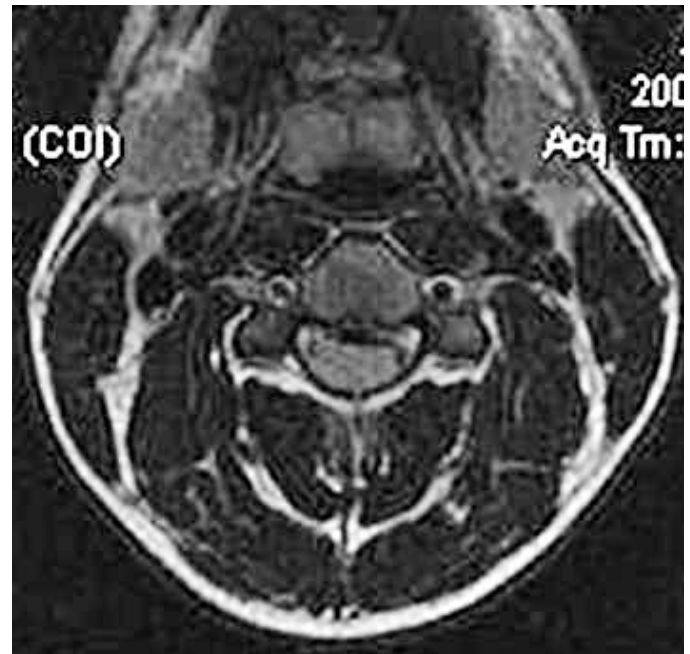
Axial view on magnetic resonance imaging of the same gymnast shown in Figure 4, demonstrating severe spinal canal narrowing with spinal cord compromise.
